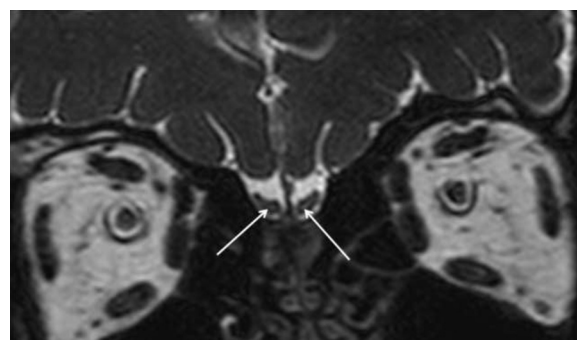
Coronal T2-weighted MR image through the olfactory bulb of patient K5, a 30 year-old patient with hypogonadotropic hypogonadism and anosmia. Central hypersignal on T2 weighted images is visible in the olfactory bulbs (white arrow). Olfactory fossae and sulcus are wide and deep whereas ethmoid angles and rectus and orbital medial gyri are normal.
